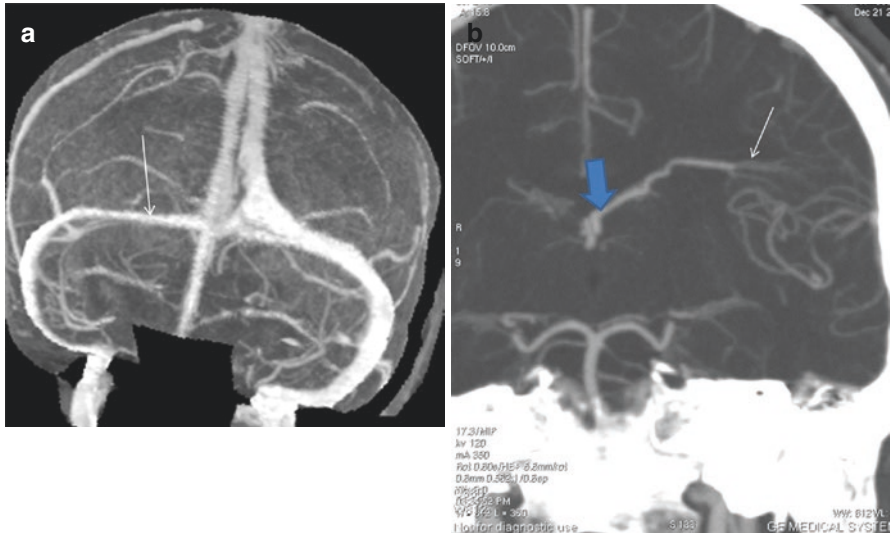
(a) CT Venography of the brain (MIP reconstructions-AP View). *White arrow* indicates the hypoplastic left lateral sinus. (b) CT Venography of the brain (coronal MPR reconstruction) shows a left-sided developmental venous anomaly (DVA). *White arrow* indicates the characteristic “medusa-head” appearance of the DVA, while the *thick blue arrow* shows the deep venous drainage into the unilateral internal cerebral vein
